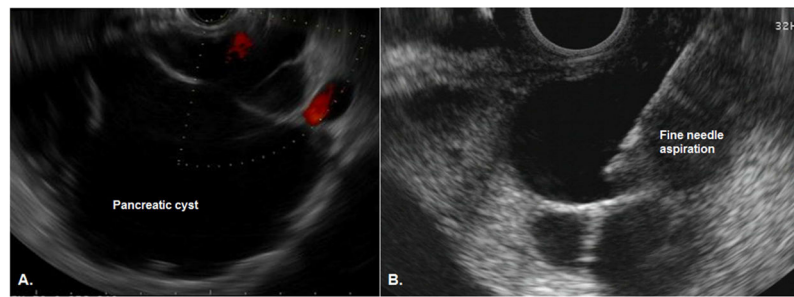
Endoscopic ultrasound of a pancreatic cyst. A) EUS image of a pancreatic cyst with thin septations. B) EUS-guided fine needle aspiration. The needle (arrow) can be seen within the center of the cyst.
